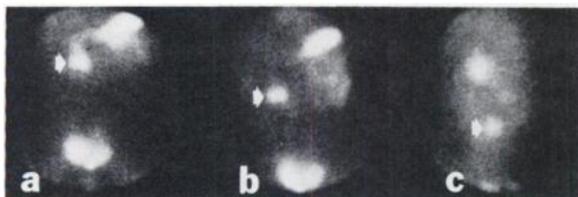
Positive scintigram showing a focus of activity (arrow) in duodenum (a). Upright anterior image (b) shows normal activity to have moved caudally (distance from stomach increased); lateral image (c) shows lesion to be intraperitoneal. Child had a Meckel's diverticulum with ectopic gastric mucosa.
